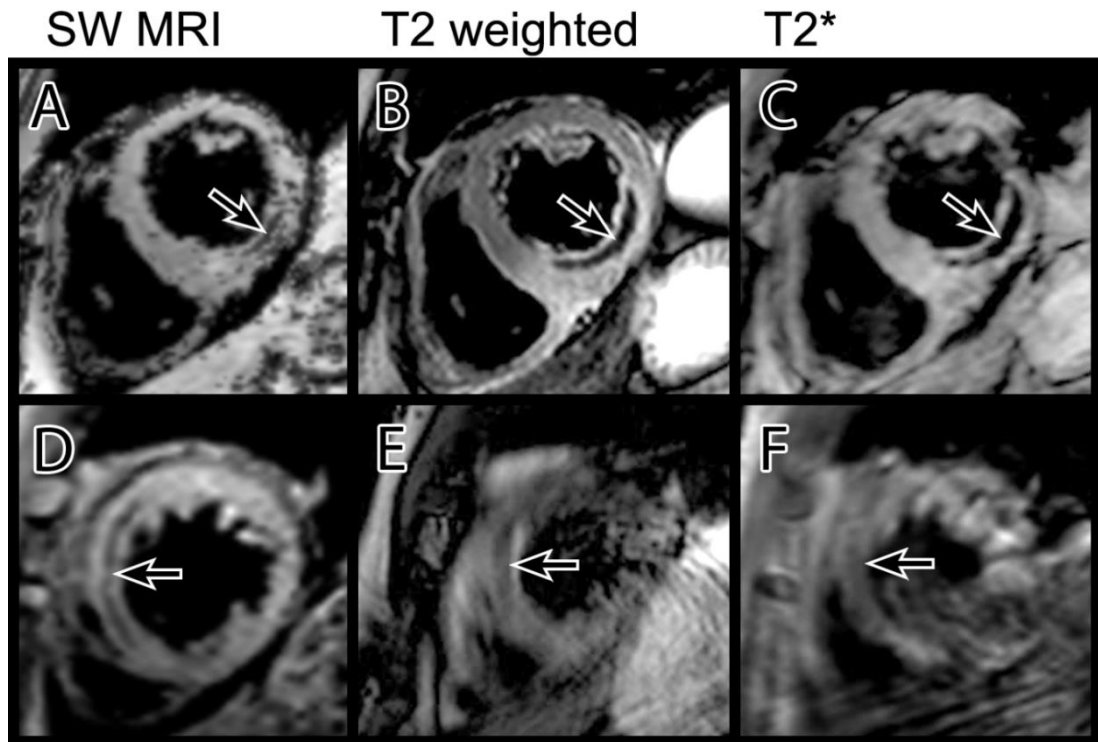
Optimal and suboptimal breath holding in SW MRI, T2w and T2\* images. Top row: a patient with good breath holding reveals clear inferior IMH on SW MRI (A), T2w (B) and T2\* (C) images. Bottom row: a different patient with anteroseptal AMI and reduced ability to breath hold has IMH visible on SW MRI (D), but T2w (E) and T2\* (F) images are suboptimal for detection of IMH.
